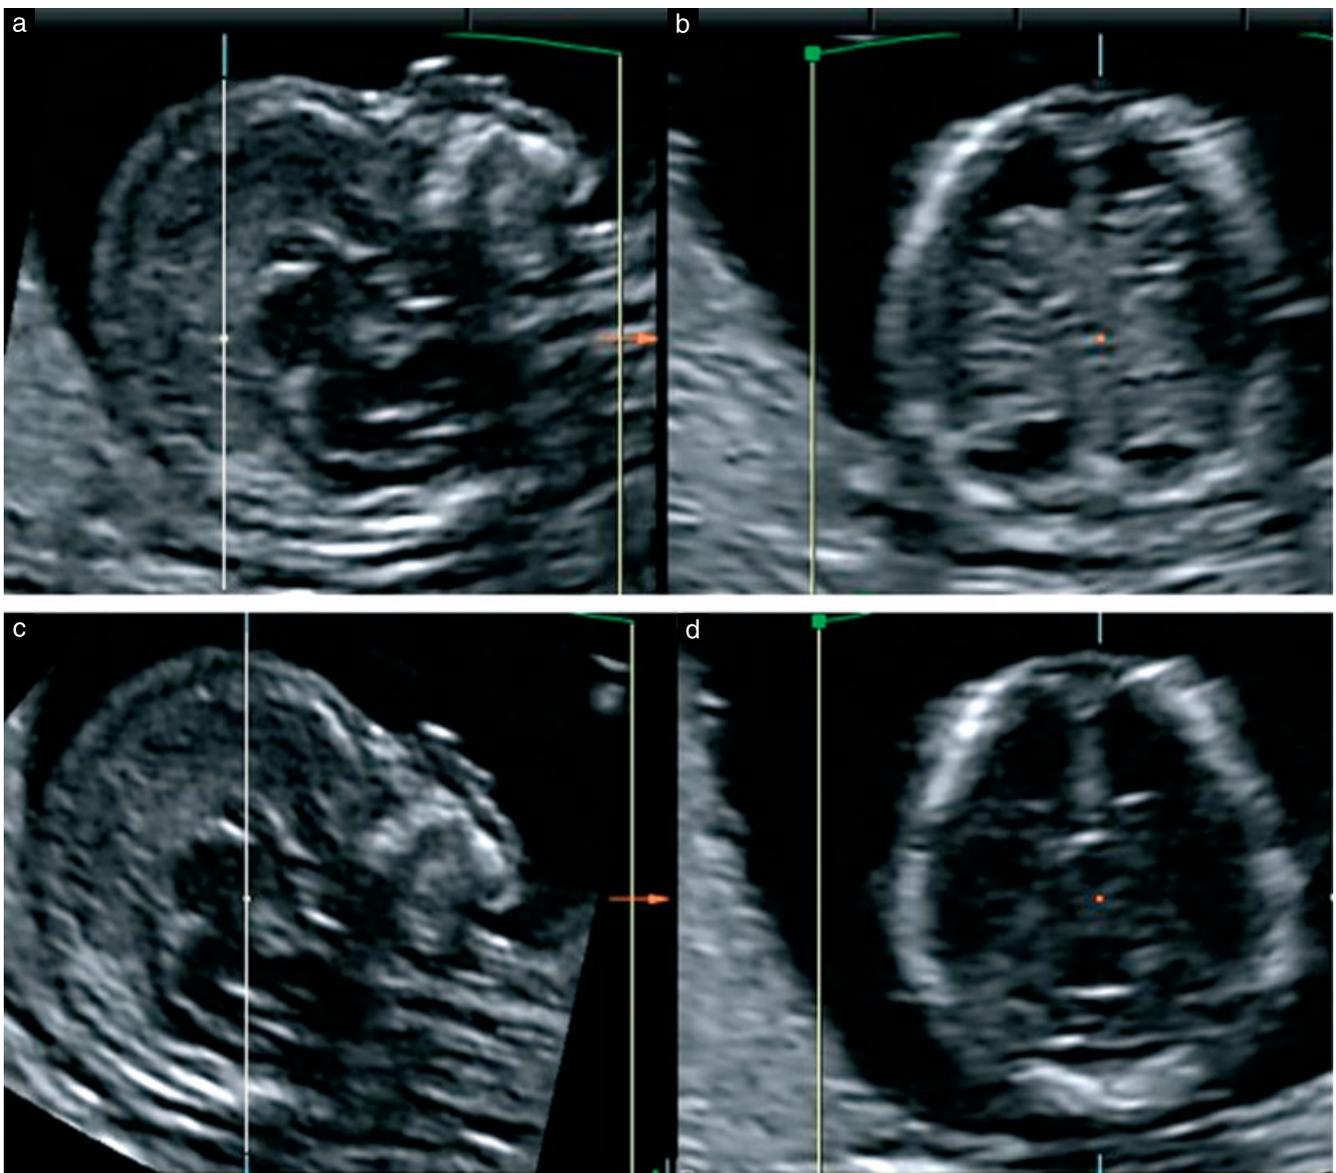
Transabdominal sonography of the fetal head at 13 + 2 weeks: three-dimensional reconstruction with sagittal (a,c) and axial (b,d) views demonstrating the different insonation planes (white lines) for measurement of the biparietal diameter (a,b) and for depiction of the posterior fossa (c,d).
